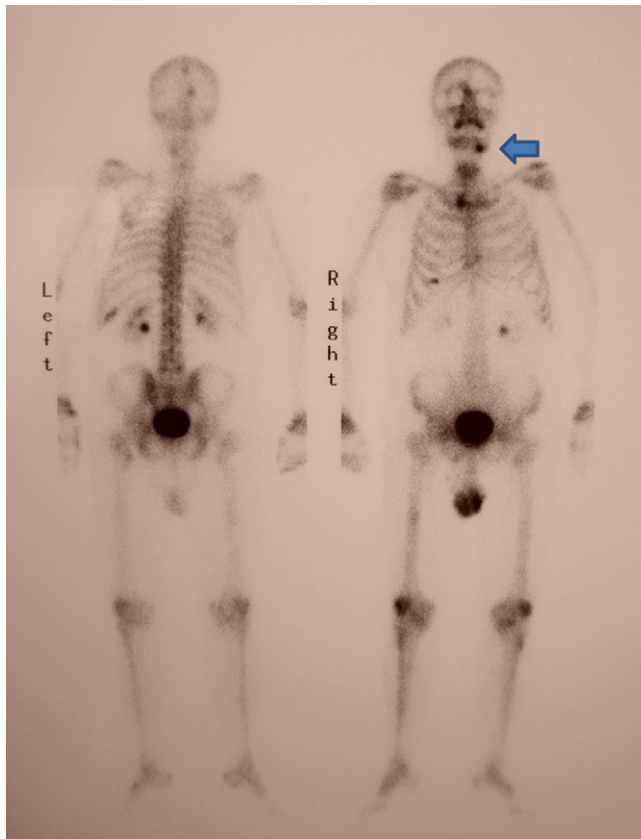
Skeletal scintigraphy showed increased uptake in the mandibular area.
